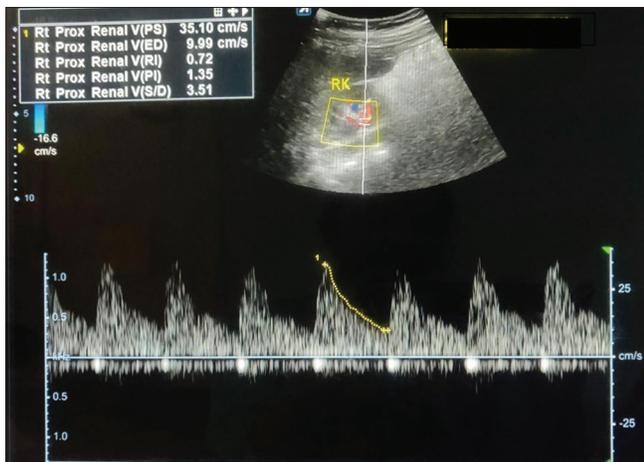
shows Colour Doppler image showing an RI of 0.72 in a normal kidney in a 4mnth male
